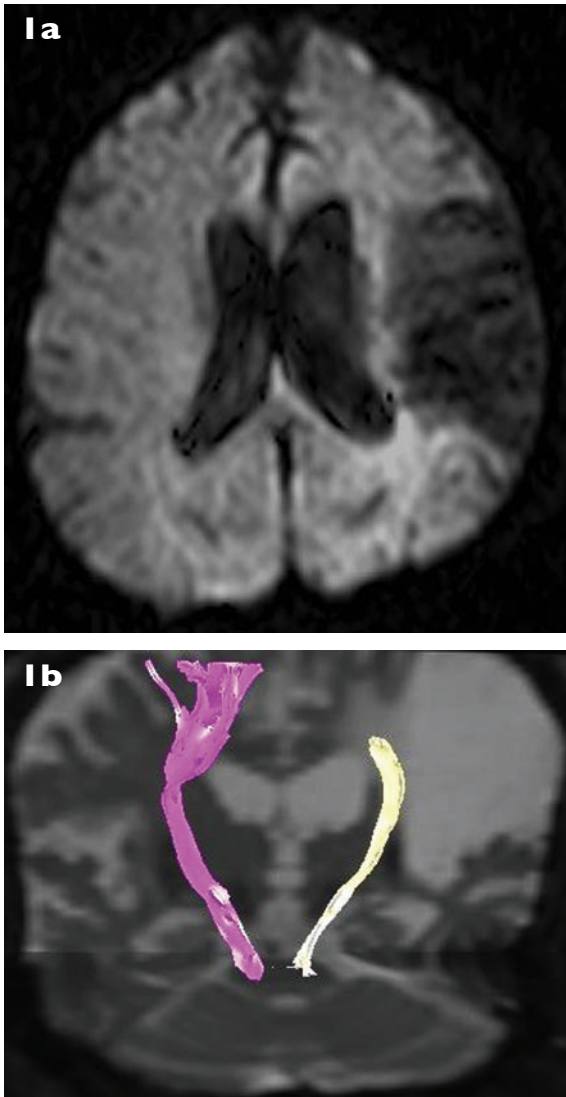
Case 1. (a) DWI shows a large chronic infarction in the left middle cerebral artery distribution. (b) MR tractography shows complete disruption of left corticospinal tract at the level of infarction with small calibre of the rest of the tract.
